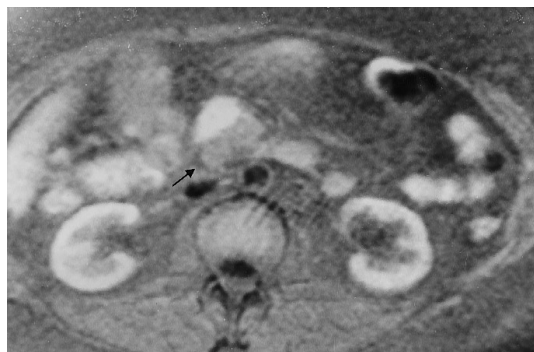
Pancreatic head carcinoma. Fat-saturated T1-weighted spin-echo (SE) sequence clearly shows a 2-cm hypointense mass (*arrow*) within the markedly hyperintense normal pancreas
